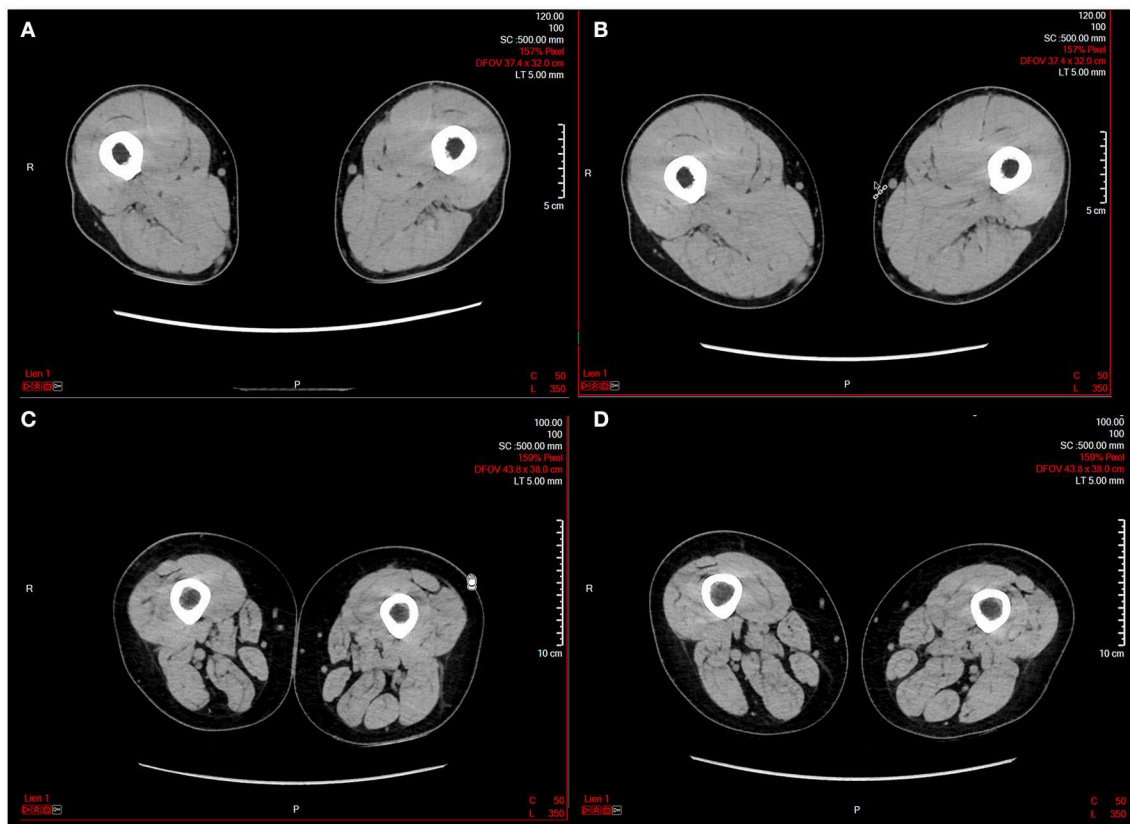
Representative computed tomography (CT) scans before and after a 16 weeks epidural electrical stimulation (EES) protocol in two patients with spinal cord injury. (A) Patient 1 before EES; (B) patient 1 after EES; (C) patient 2 before EES; (D) patient 2 after EES. The images have been kindly provided by Prof. G. Courtine and J. Bloch.
